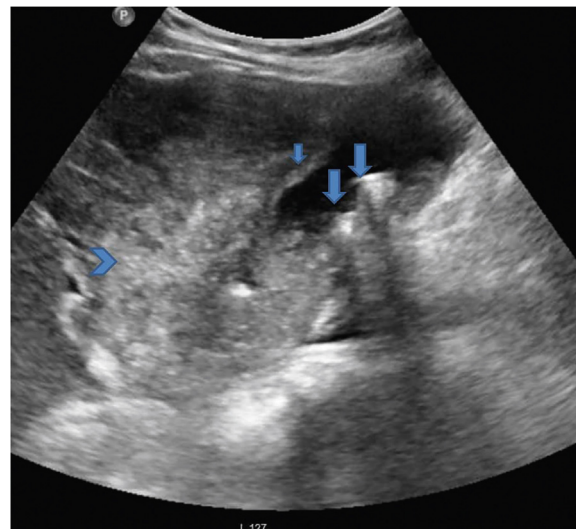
Gray-scale US image shows multiple GB calculi (arrows), GB wall thickening (short arrow) and ill-defined heterogeneous mass arising from the neck of GB (arrow head). CT scores over US in depicting the true extent of adjacent liver invasion.
